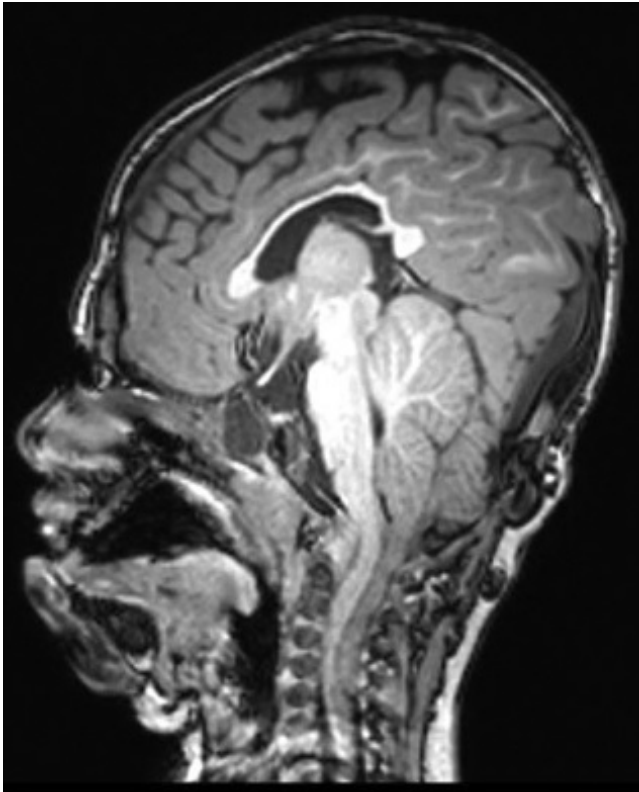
MRI scan showing a child with Crouzon syndrome with significant tonsillar herniation below the foramen magnum. Bicoronal synostosis has resulted in a significant brachycephaly deformity resulting in decreased posterior cranial fossa volume and a cramped cerebellum.
